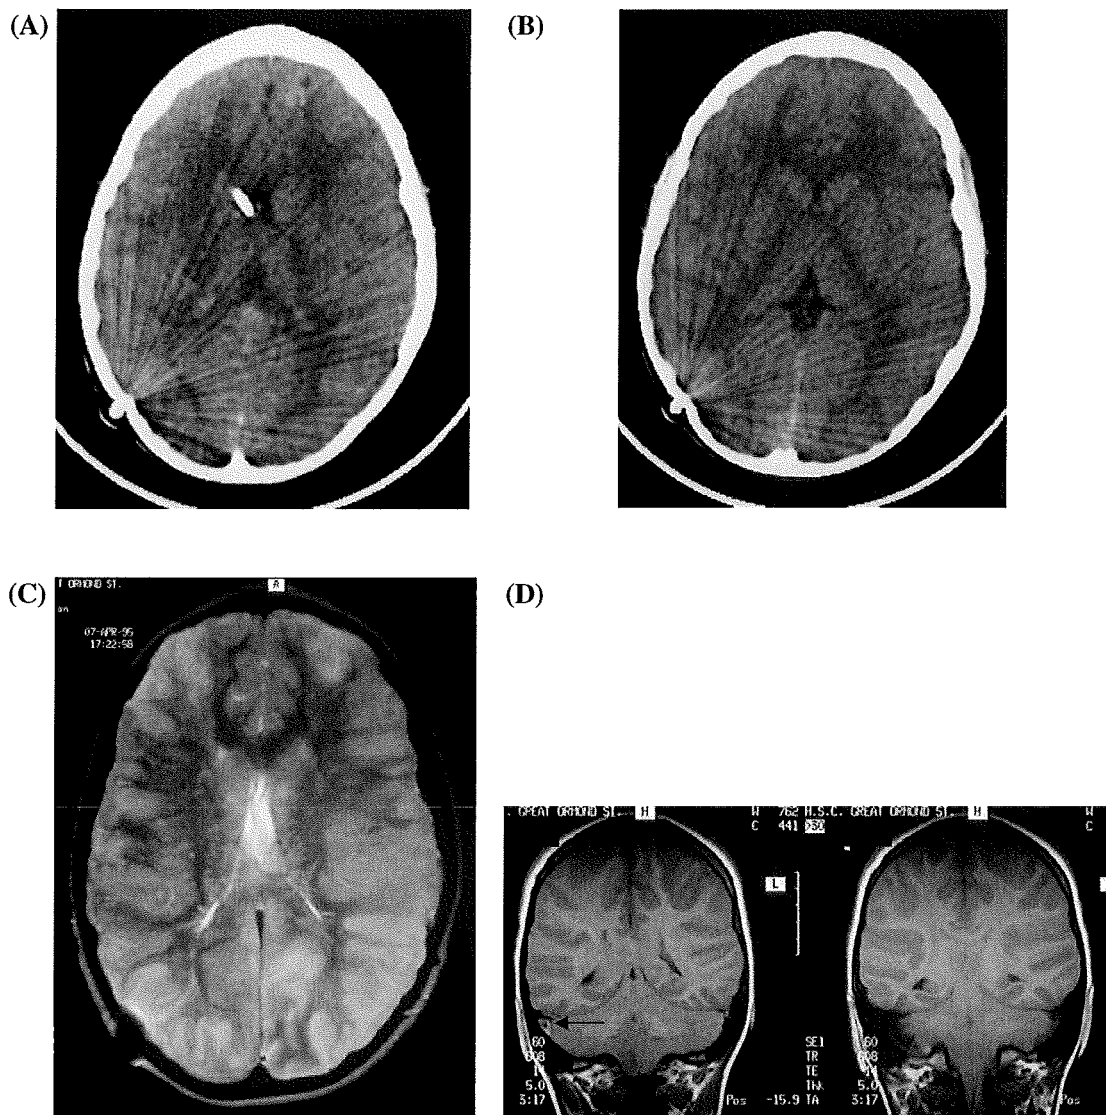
(A) This child with haemoglobin SC disease had presented in infancy with seizures and had required a shunt for hydrocephalus. He represented at the age of 9 with severe chronic headache and 3 weeks later developed generalized seizures. There are no visible sulci and the ventricles are small on the initial CT scan, indicative of cerebral oedema. A right-sided shunt and intracranial pressure monitor are noted. (B) The CT scan at 10 days shows definite cerebral oedema and the dense straight sinus raises the possibility of CSVT, but is not diagnostic. (C) Two days later there is widespread cortical and basal ganglia high signal on T2-weighted axial MRI. (D) Marked swelling of the cerebral hemispheres and posterior fossa, which has led to tonsillar descent, is seen on the T1-weighted coronal images. High signal is seen in the right transverse sinus (delta sign) due to either slow flow or thrombus (arrow).
